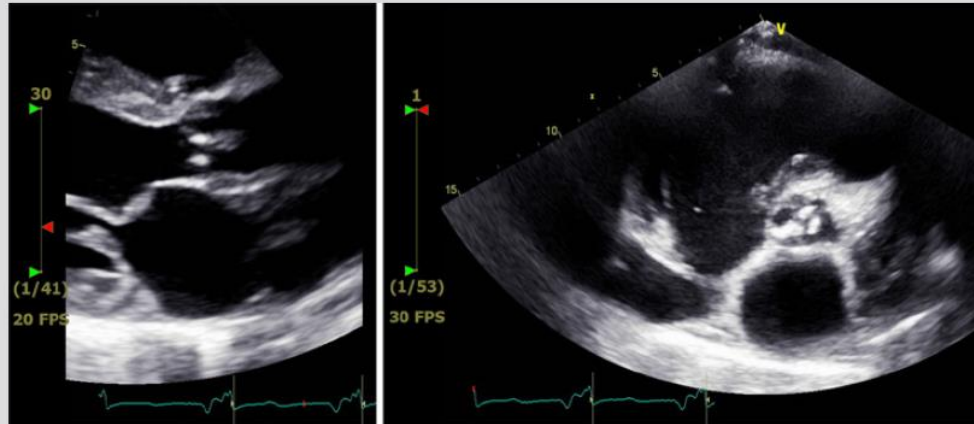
Echocardiogram showing aortic valve vegetation
